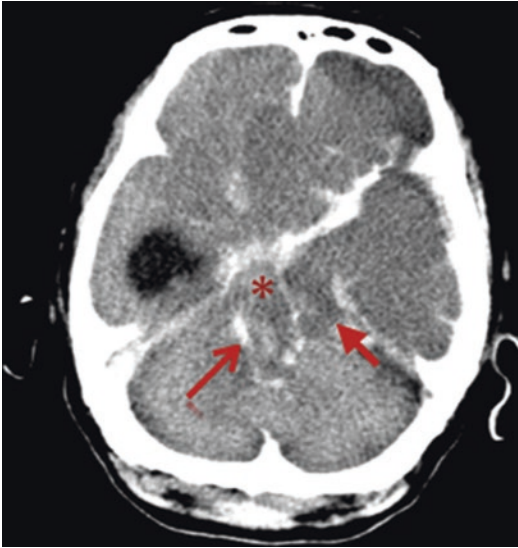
Axial brain computed tomography image of a left descending transtentorial brain herniation. The median displacement of the left uncus (broad arrow), narrowing of the midbrain (asterisk), and Duret hemorrhage (narrow arrow) can be seen. The brain cistern around the midbrain is effacing and there is contralateral dilatation of the lateral ventricle
